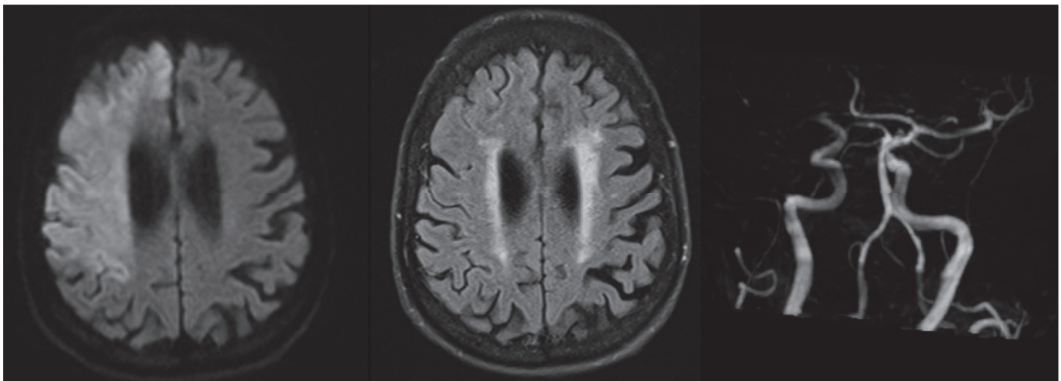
Example of MRI DWI-FLAIR mismatch in a patient with occlusion of right terminal internal carotid artery.
